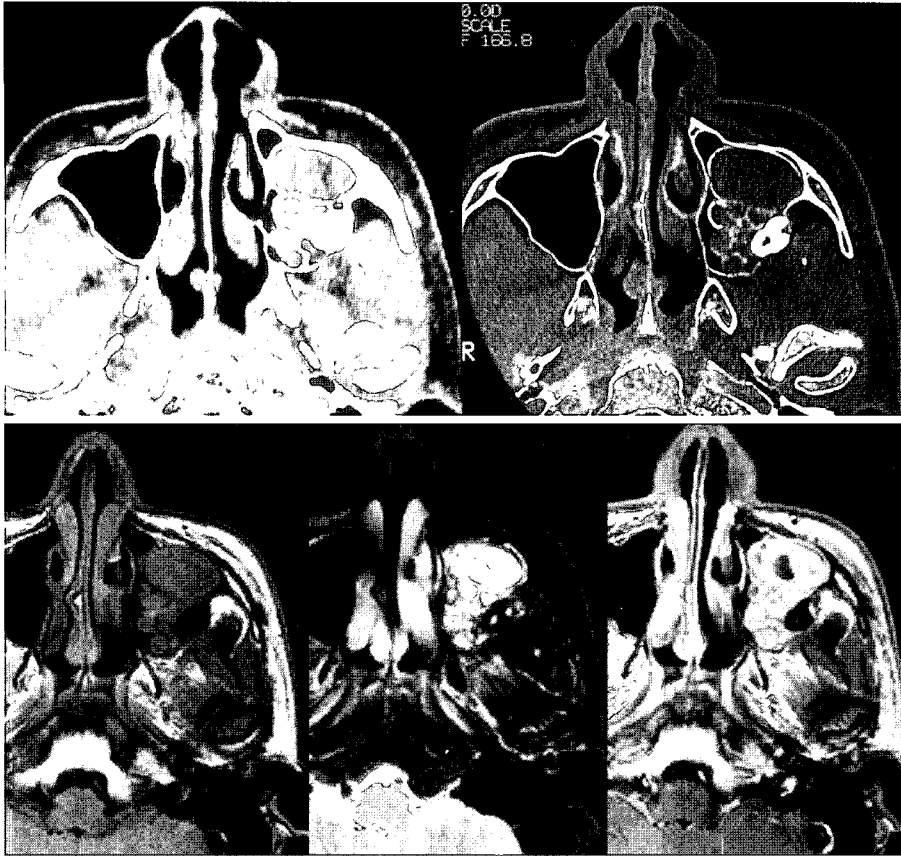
CT reveals a lesion with the internal round trabeculations in the left maxillary sinus. Axial T2 weighted MRI shows a lesion of heterogeneous high signal intensity with round and no signal intensity areas corresponding to the internal round trabeculations and the ossified areas on CT. The enhanced T1-weighted scan shows slightly enhanced capsular structures.
